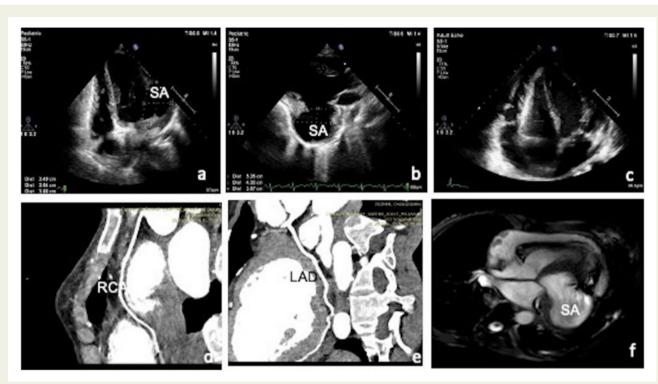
Figure I Echocardiogram showing large submitral aneurysm (SA) measuring approximately (A) in A4C view 3.8 cm \times 3.6 cm with a neck diameter of 3.5 cm. (B) in PLAX view 5 cm \times 4 cm with a wide neck of size 3.67 cm. (C) Echocardiogram showing pericardial effusion with multiple thick strands and organized fluid at some places. (D and E) Computed tomography coronary angiogram showing no obstructive lesions in right coronary artery (D) and left anterior descending artery (E). (F) Cardiac magnetic resonance (CMR) bright blood image [frame from cine steady state free precession (SSFP) sequence] in 4Ch-view showing the large submitral aneurysm.
